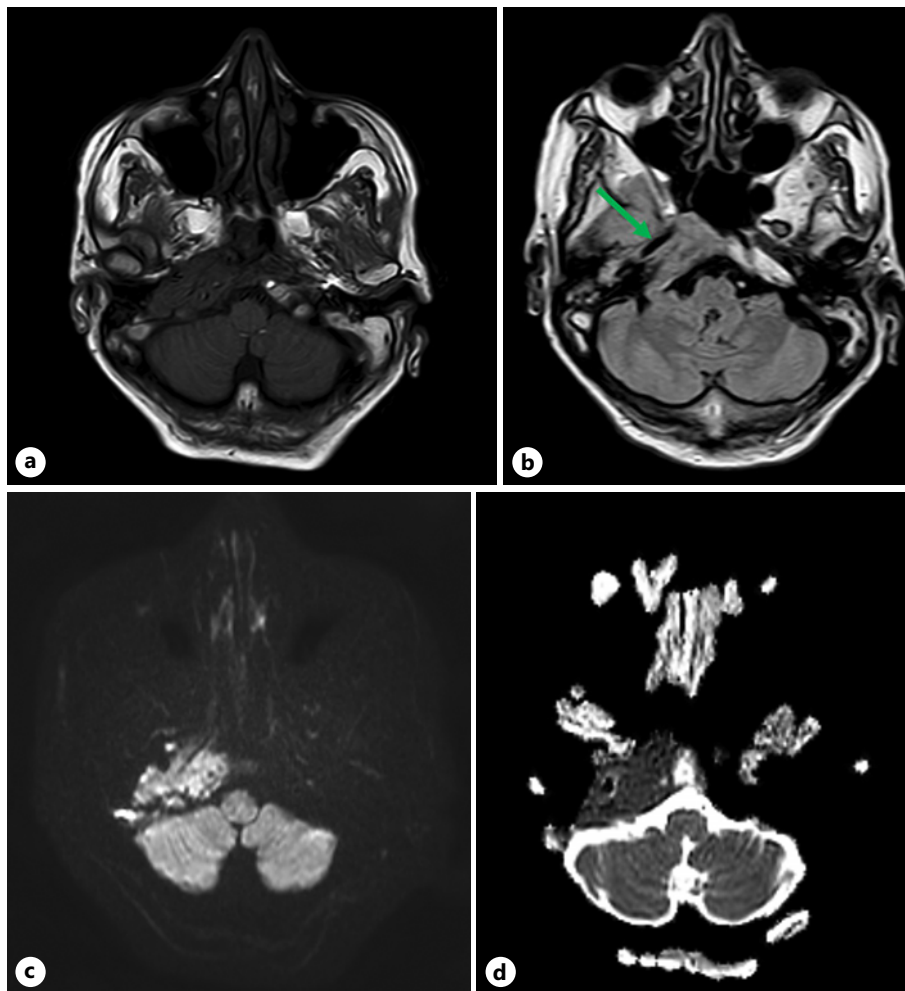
Brain MRI axial images: T1 weighted (a), FLAIR (b), diffusion-weighted sequences (c), and apparent diffusion coefficient (ADC) (d) map reveal extensive signal changes of the right petrous apex, encasing ipsilateral carotid artery (green arrow in b), with diffusion restriction.
